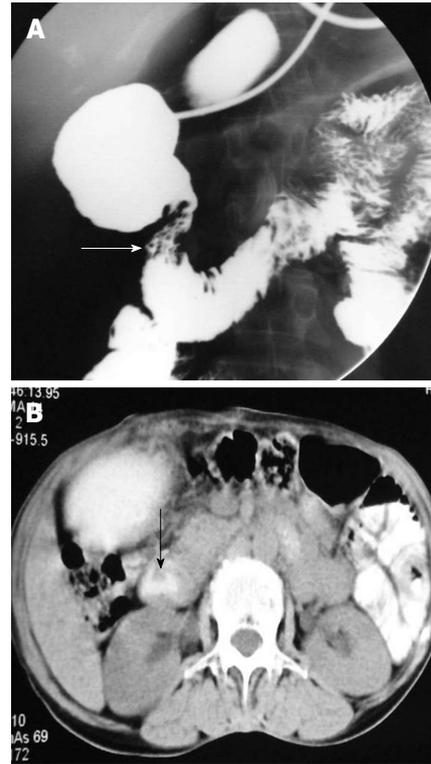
Upper gastrointestinal barium study (A) demonstrates smooth circumferential extrinsic narrowing of the second part of the duodenum (arrow), axial computed tomography image (B) shows pancreatic parenchyma incompletely surrounding the duodenum (arrow), features suggestive of partial annular pancreas.
